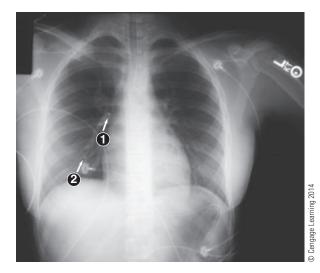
Head injury. The chest radiograph is normal. The small round markings (1 and 2) are the pulmonary blood vessel running parallel to the roentgen ray (X-ray).
